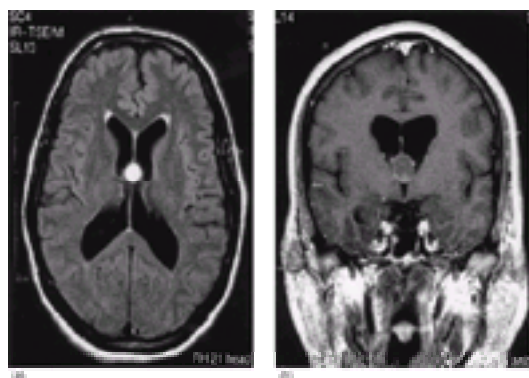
(a) Axial and (b) coronal magnetic resonance images demonstrate a colloid cyst occluding the foramina of Monro and causing obstructive hydrocephalus.
